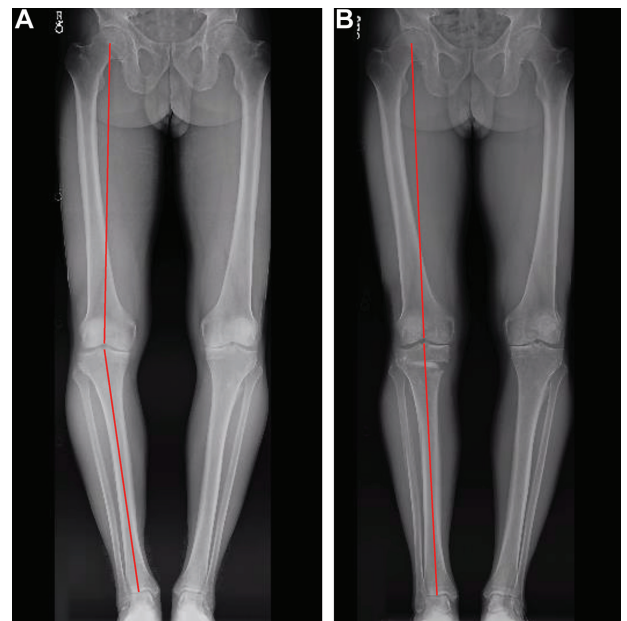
(A) A preoperative long-leg alignment radiograph demonstrating a hip-knee-ankle angle of 9.2° of varus. (B) A long-leg alignment radiograph after high tibial osteotomy with correction to 0.1° of valgus.
